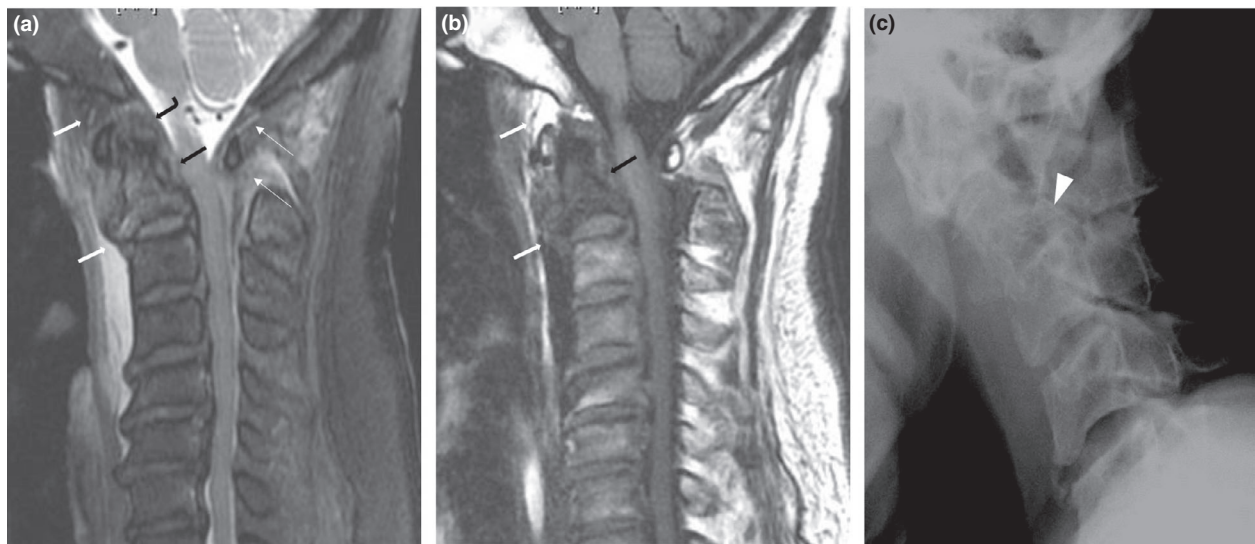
CCJ injury in a 67-year-old male. Mid-sagittal (a) STIR and (b) T1-W MR images show C2 oedema and cortical discontinuity, AAOM and AAAM tears (thick white arrows), tectorial membrane (black bent arrow) and transverse ligament tears (thick black arrows), PAOM and PAAM tears (thin white arrows). Also seen are prevertebral fluid and ALL injury from C3-5 levels. (c) Corresponding radiograph shows a fracture of the odontoid process (arrowhead). Tectorial membrane, transverse and alar ligamentous injuries may occur together and cause disruption of the atlanto-axial relationship. It is advisable to look for associated C1 and C2 fractures, avulsion fractures at the lateral processes of the atlas (indicating transverse ligament injury) or occipital condylar avulsions (indicating alar ligament injuries).
